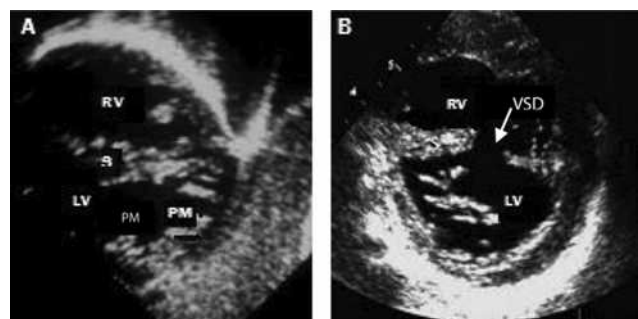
Two dimensional echocardiography in cases with situs solitus: subcostal short axis view (A) and parasternal short axis view (B) at mid - ventricular level showed superior RV - inferior LV (recognized by the presence of two papillary muscles) and horizontal alignment of interventricular septum.
